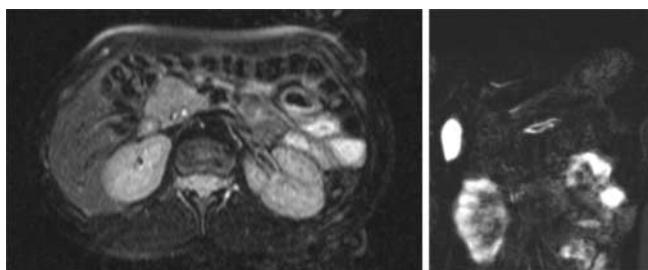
MRI image. Focal mass in the head of the pancreas. Widened pancreatic duct, doubled in the distal part. Material of the Department of Diagnostic Imaging, The Children's Memorial Health Institute, Warsaw, Poland
